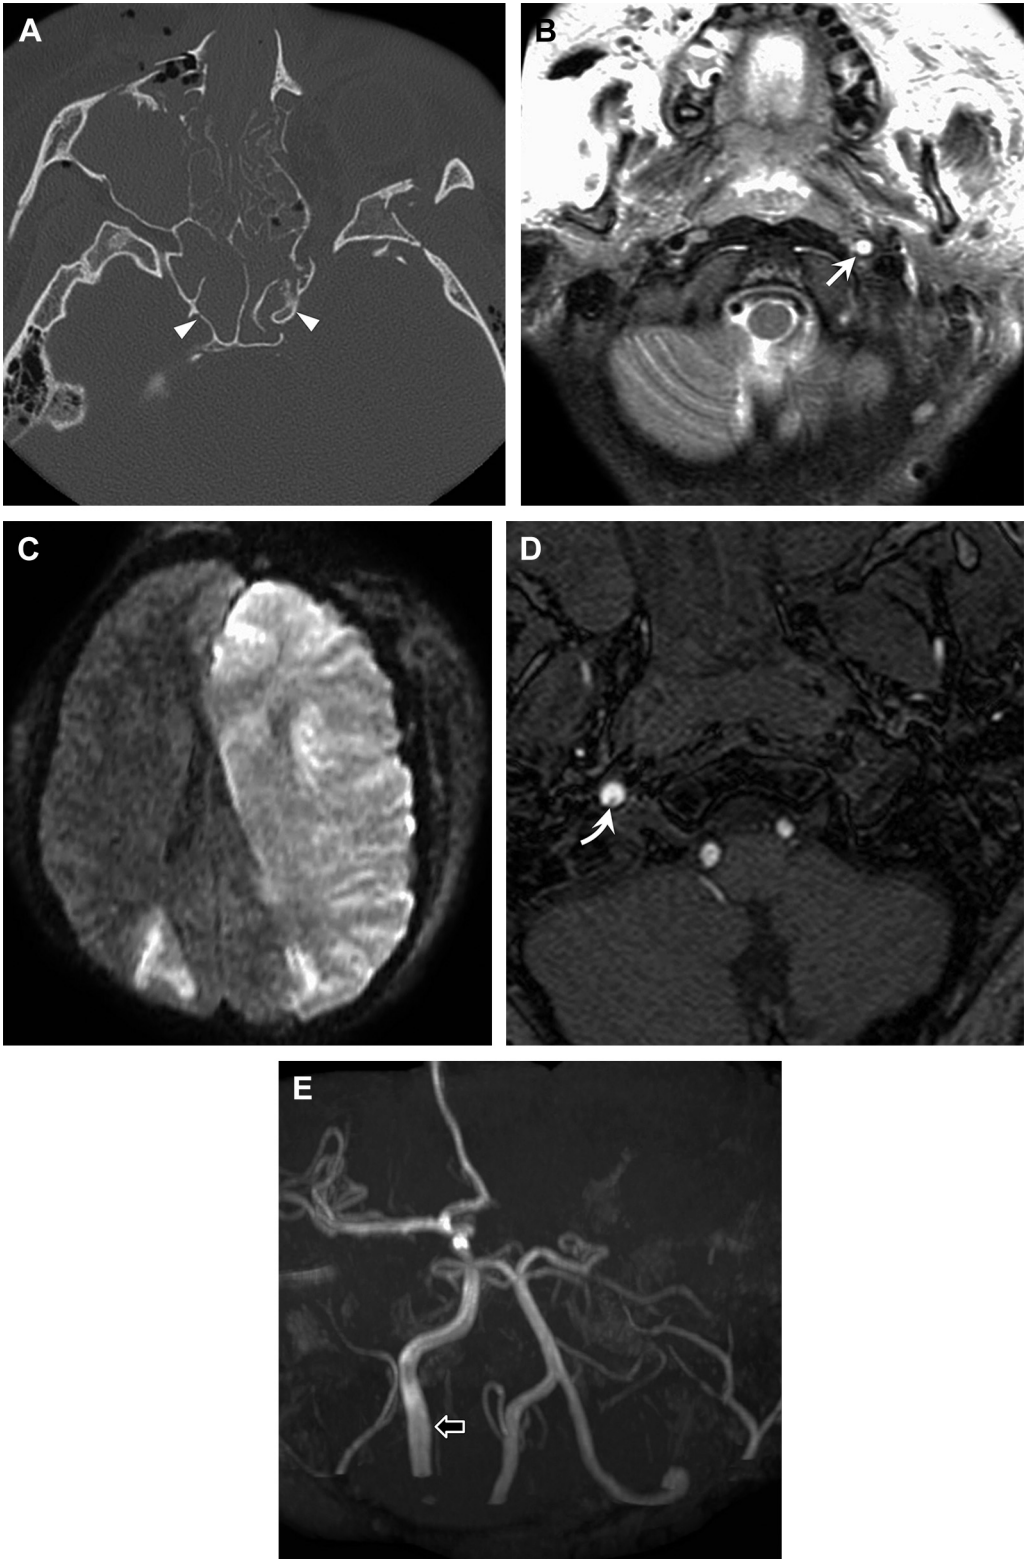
Traumatic right internal carotid dissection and left internal carotid occlusion. (A) Axial CT shows bilateral fractures of the carotid canals (*arrowheads*) with more severe displacement on the left. (B) Axial T2-weighted and (C) diffusion-weighted MR images reveal a left carotid occlusion (*arrow*) and bilateral hemispheric infarcts, greater on the left. (D) 3D-TOF source and (E) maximum intensity projection (MIP) MRA images reveal a lack of flow in the left ICA and a dissection flap of the right ICA (*curved arrow*). The MIP image reveals slight overall enlargement of the distal right ICA (*open arrow*) but does not clearly reveal the dissection itself.
